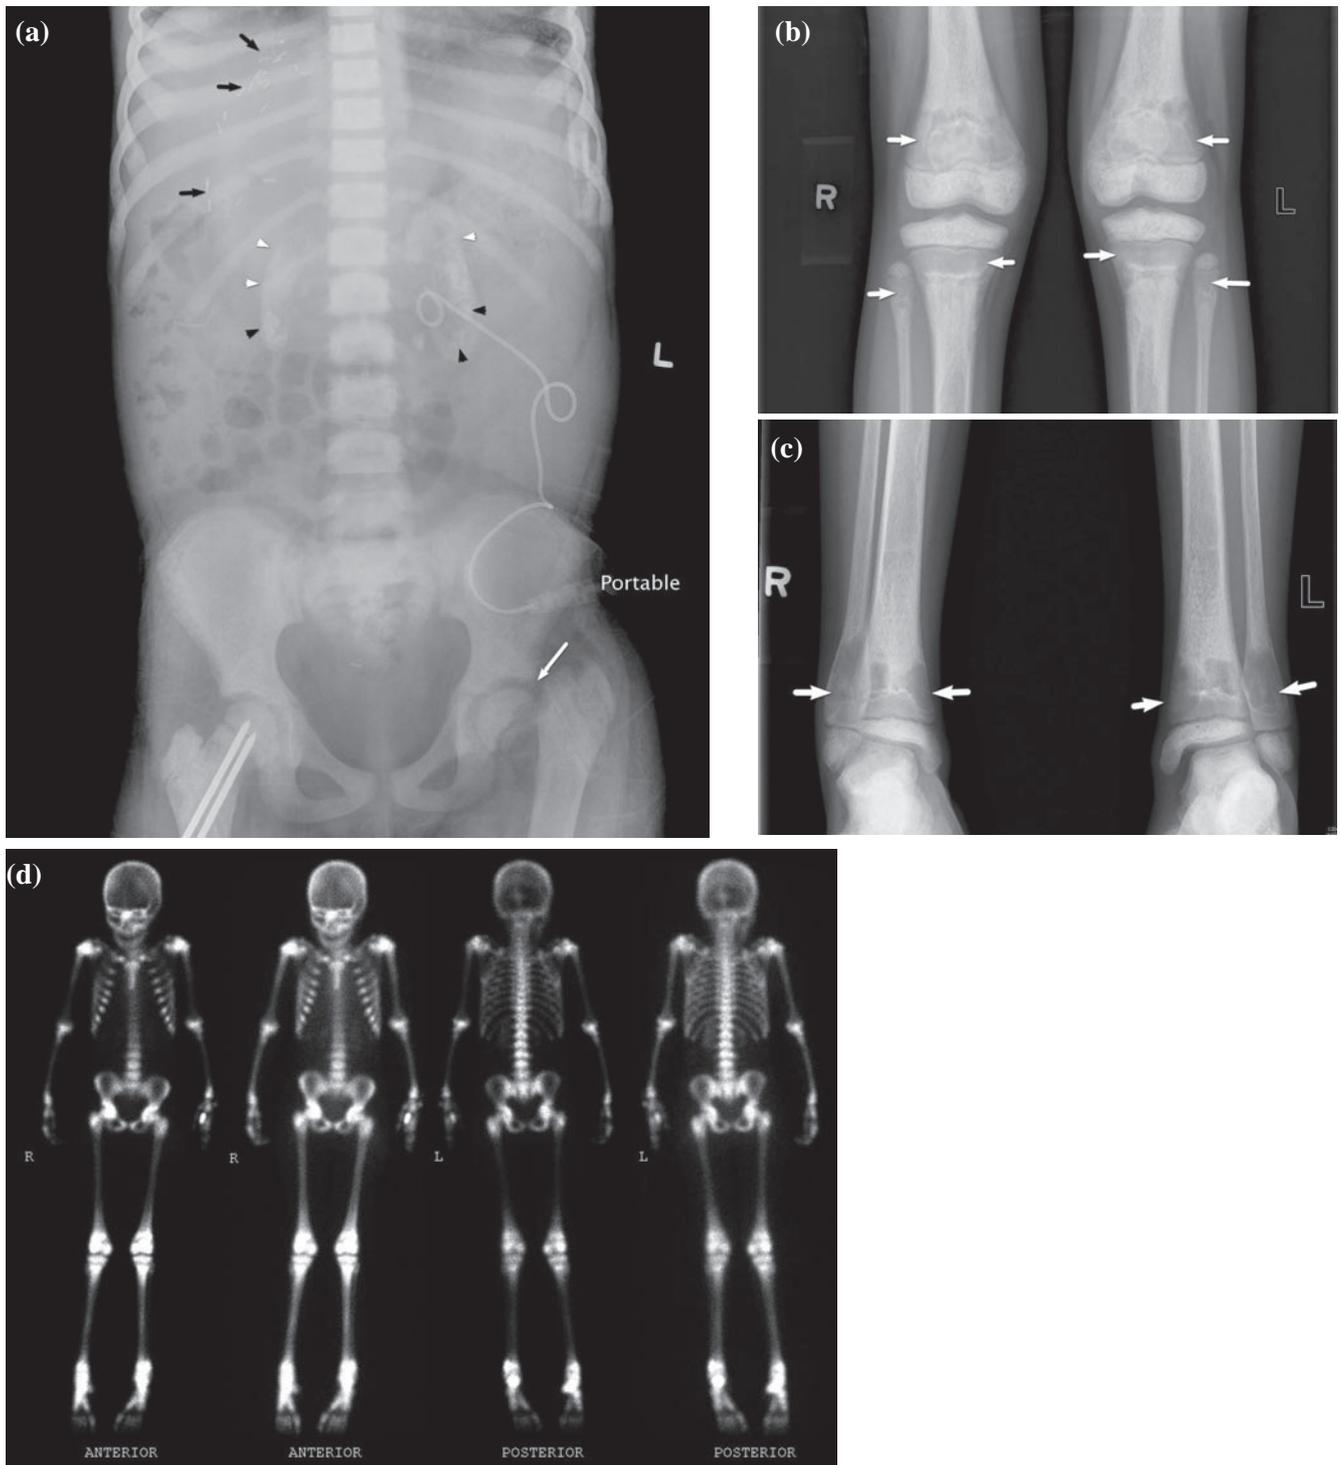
(a) An abdominal radiograph showed markedly increased densities of both kidneys (white arrowheads), multiple bilateral renal stones (black arrowheads) and a displaced pathological fracture over the left femoral neck (white arrow). Surgical clips over the right upper quadrant of the abdomen (black arrows) were due to liver transplant. A left percutaneous nephrostomy tube and two fixation pins over the right femoral neck were in-situ. Generalised increased in bone densities with osteosclerosis along the vertebral column were also evident. (b & c) Conventional radiographs of bilateral lower limbs showed symmetrical, wide and translucent metaphyses of bilateral distal femurs, proximal and distal tibias and fibulas (white arrows). The diaphysis of these bones showed markedly increased densities and coarsened trabeculation. (d) Whole body bone scan images in anterior and posterior projections showed markedly increased tracer uptake in the whole skeleton, especially over the periarticular regions of peripheral long bones. Renal and soft tissue activities were reduced. No activity in urinary bladder was detected.
